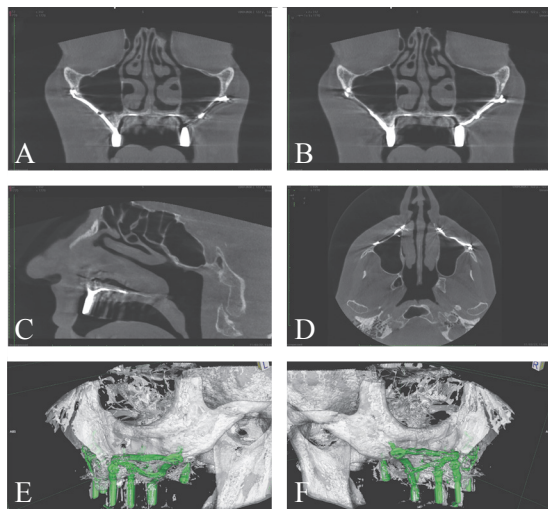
Cone Beam Computed Tomography (CBCT) evaluation at 2 years after the surgery. The different projection (A-F) showed the good interaction between the implant and the underlying bone.
